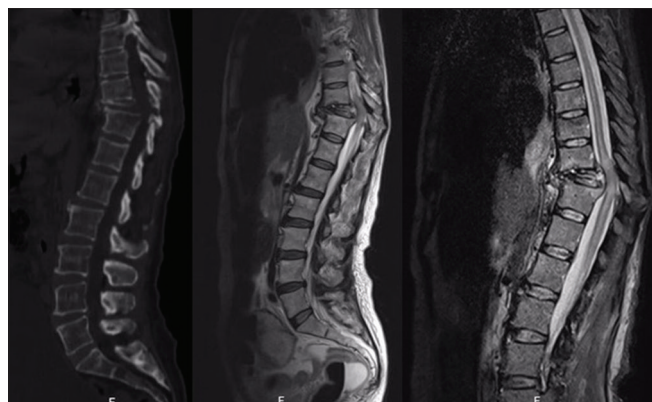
Thoracolumbar computed tomography and magnetic resonance imaging (T2W1 and short-time inversion recovery) showing extensive destruction of D10 with significant retropulsion in the spinal canal, cord compression and kyphotic deformity
